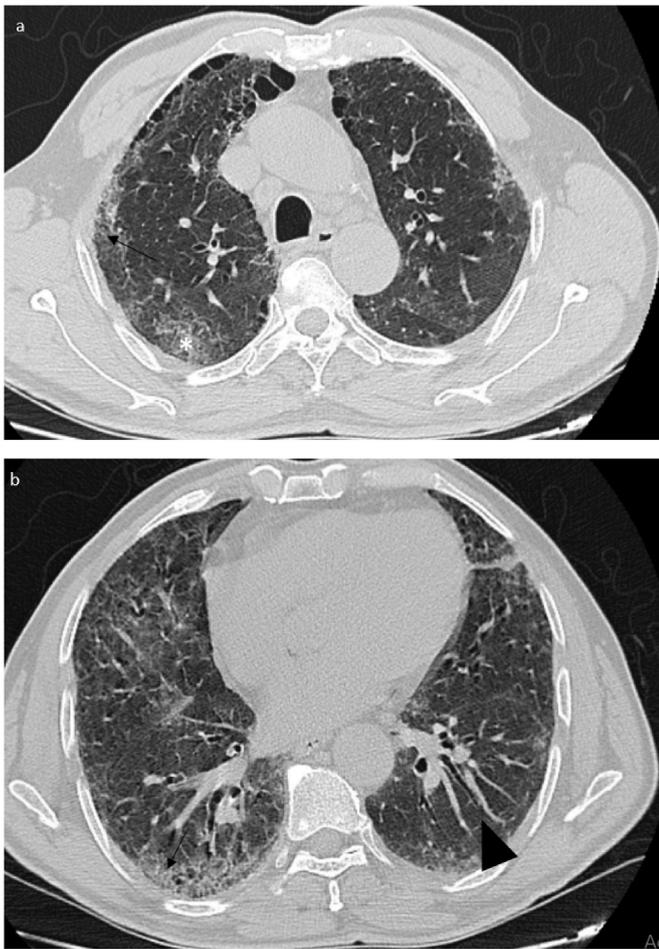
A 68-year-old male patient with COPD and severe coronavirus disease, 3 months following discharge. Axial non-enhanced chest CT images in lung window (a,b) showing bilateral involvement with residual light GGO (*), subpleural interlobular septal thickening (Black arrow), bronchiectasis, and vascular dilatation (Black arrow head).
